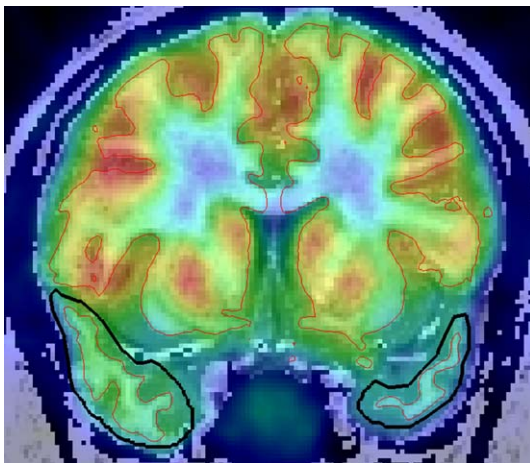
Example of co-registered MRI–PET scan in coronal view demonstrating the temporal pole regions of interest (black outline).
